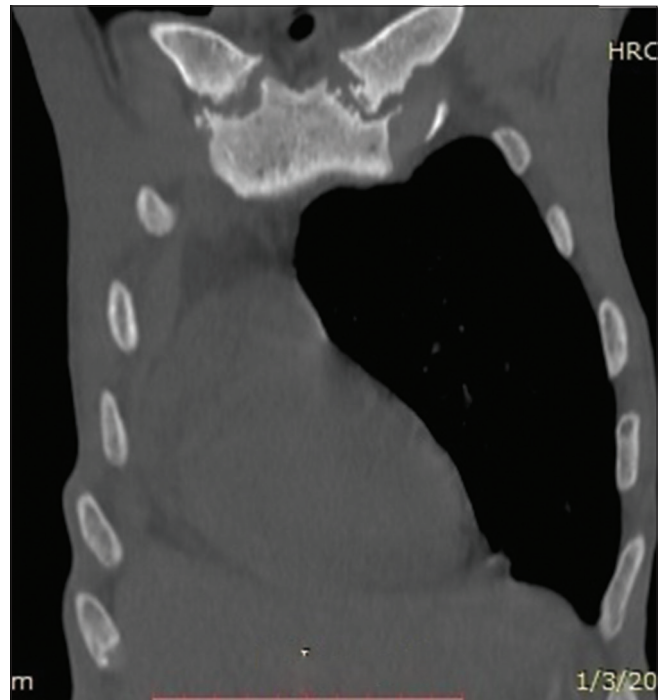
Coronal reformatted CT image of thorax showing osteitis and arthropathy at bilateral sternoclavicular joint
